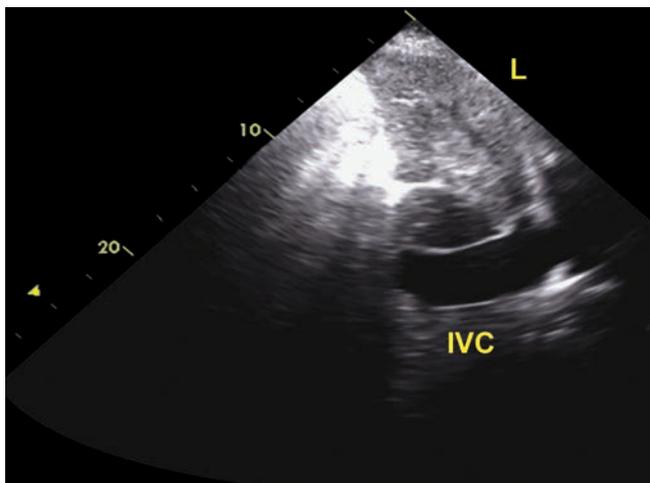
Follow-up transthoracic echocardiography shows significant dilatation of IVC.
